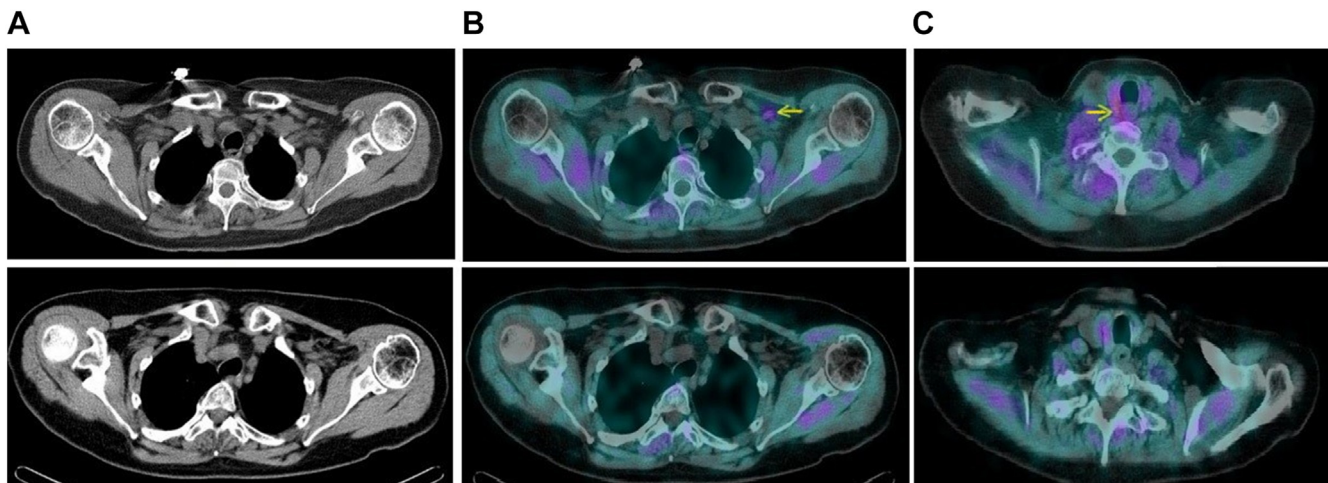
Line 1: Initial parathyroid scintigraphy [A] Axial CT [B] SPECT, images at the level of the *Left* midclavicular region with nodular uptake adjacent to *Left* subclavian vein was interpreted as concerning for parathyroid adenoma. Yellow arrow pointing to the area of interest. [C] SPECT images on the initial parathyroid scintigraphy at the level of the inferior thyroid gland. Nodular uptake along the posterior inferior *Right* thyroid gland was interpreted as concerning parathyroid adenoma. Yellow arrow sign pointing to the area of interest. Line 2: Subsequent parathyroid scintigraphy [A] Axial CT [B] SPECT image at the level of the *Left* subclavian vein This was interpreted as negative for ectopic parathyroid adenoma. [C] SPECT images on the subsequent parathyroid scintigraphy at the level of the inferior thyroid gland. This was interpreted as negative for parathyroid adenoma. CT = computed tomography; SPECT = single-photon emission computed tomography.
